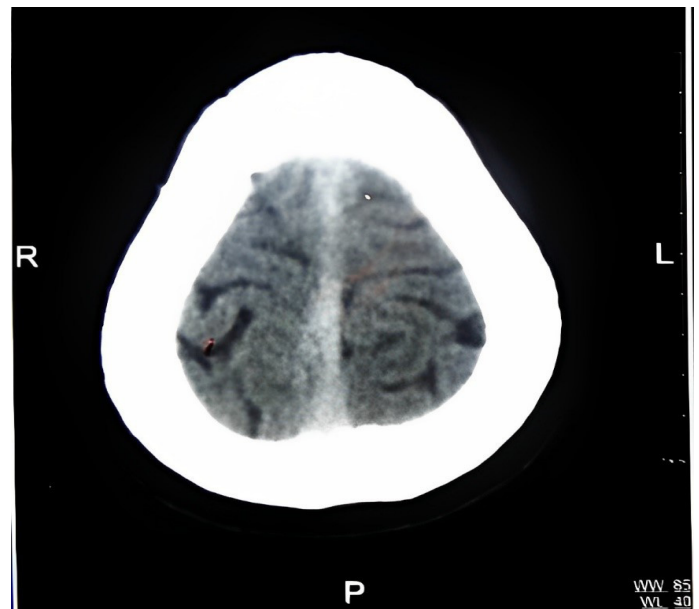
Axial, noncontrast computed tomograph of head, taken ten days after head injury, showing hyperdensity along superior sagittal sinus.
